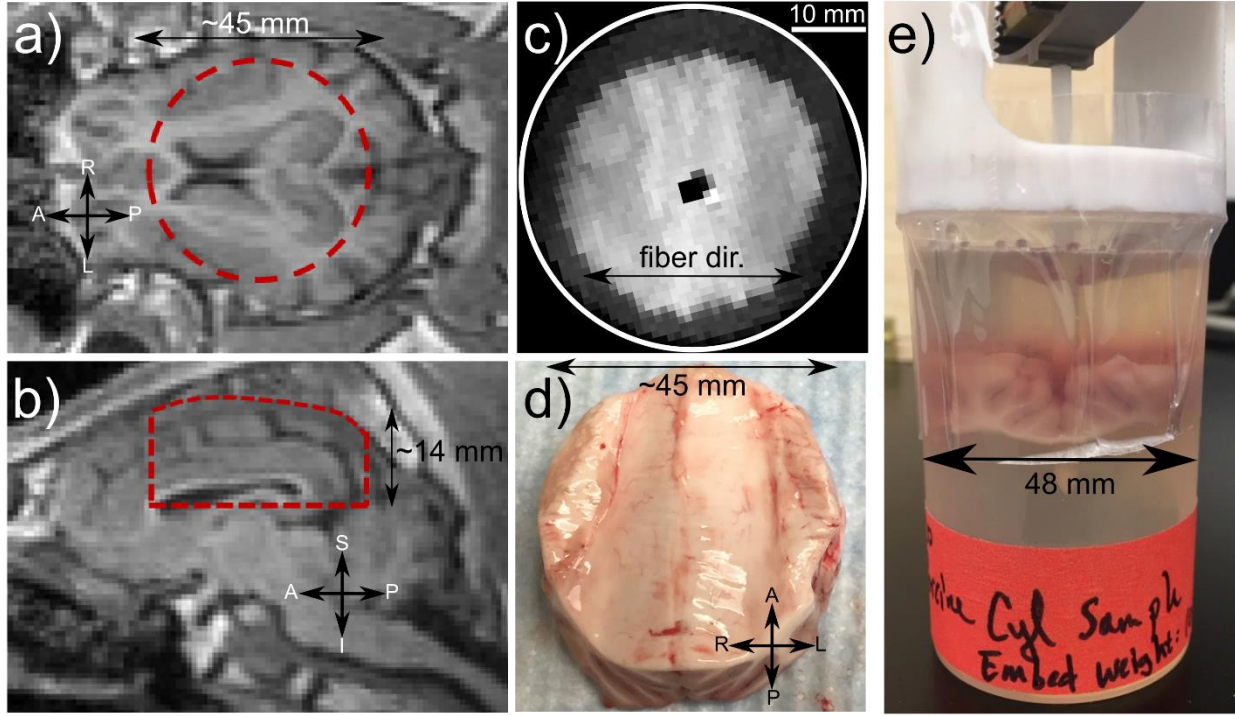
(a-b) T1-weighted (T1W) *in vivo* anatomical images from prior work (Bayly et al., unpublished) showing tissue volume used for current study (red dashed outlines). (c) T1W images of *ex vivo* sample used in the current study. Fiber orientation is left-to-right. (d) Photo of *ex vivo* sample of brain tissue used for this study. (e) Apparatus for MRE experiments: tissue embedded in gel inside cylindrical container, excited by harmonic motion of a central axial stinger.
